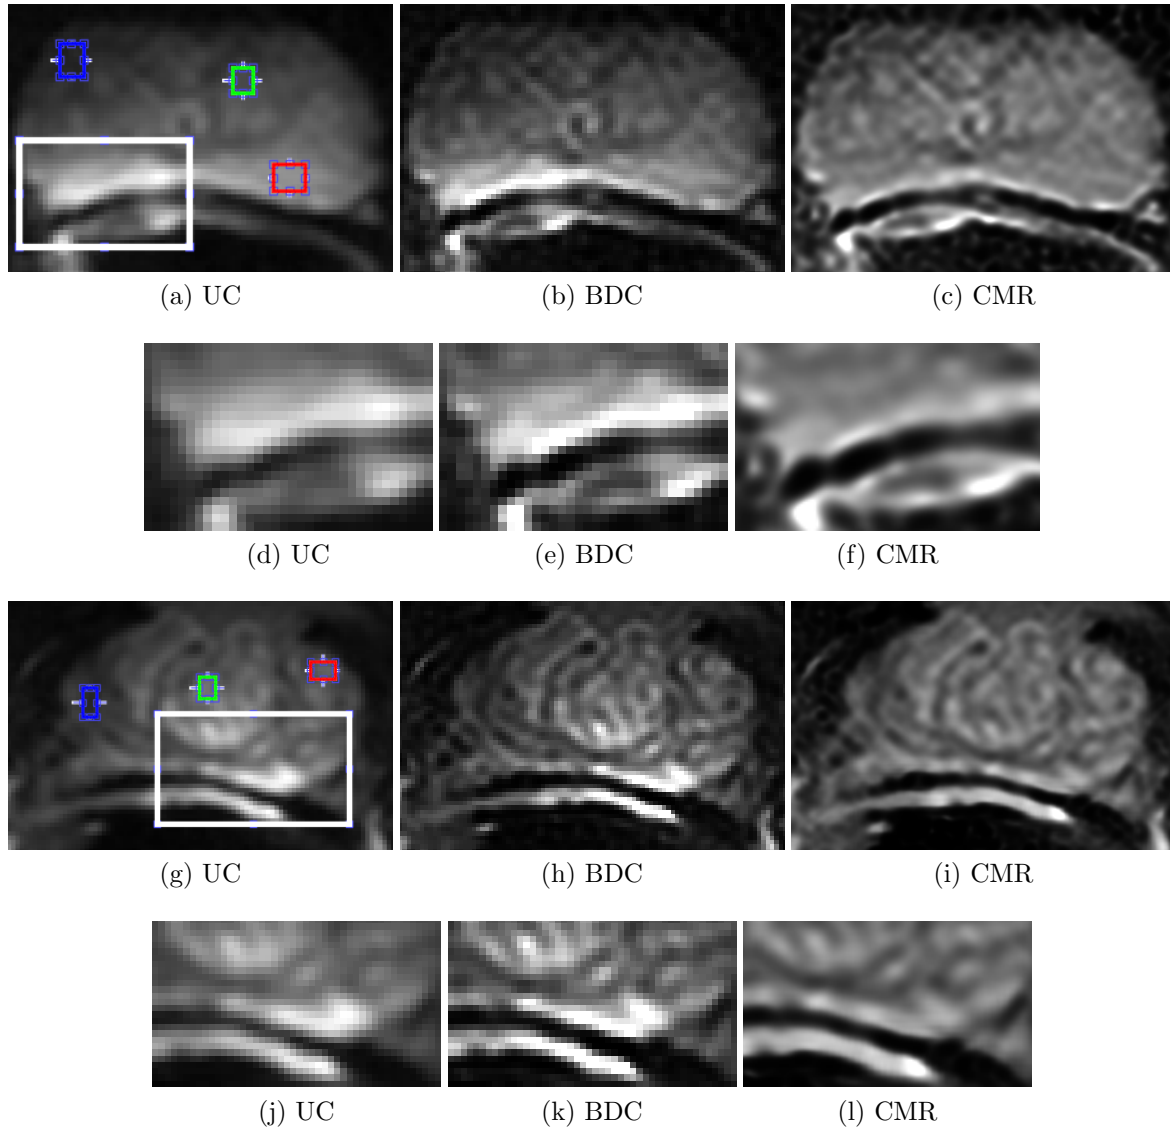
DW-MR slices of prostate gland (a,g). Compensated DW-MR images using (b,h) BDC method and (c,i) proposed CMR imaging. (d-f) and (j-l) are zoomed regions marked with white boxes on uncorrected (UC) DW-MR images of (a) and (g).
